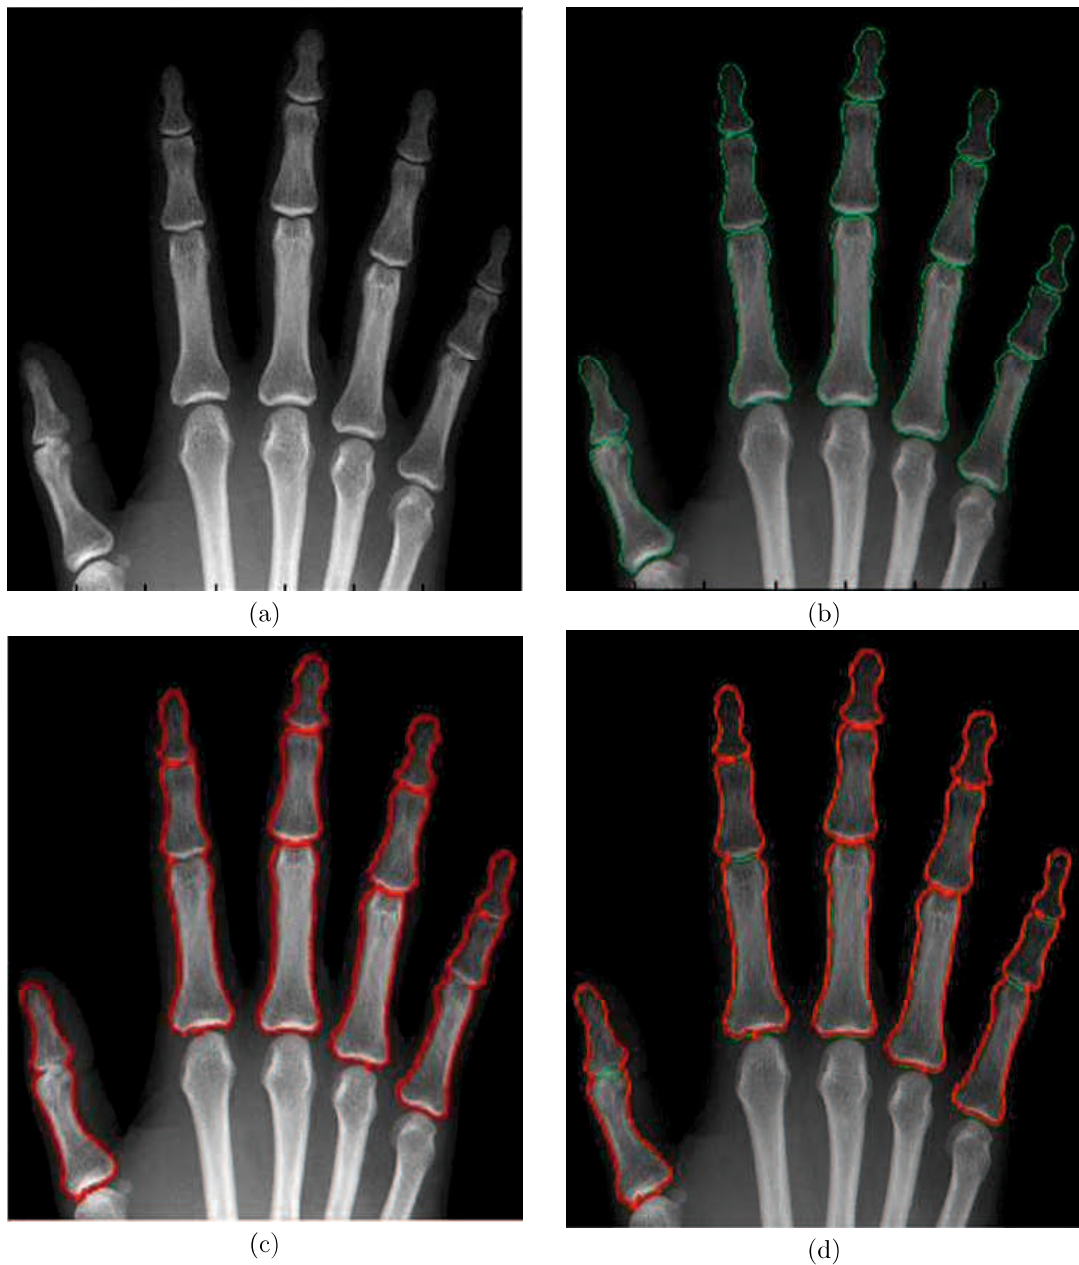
The bone boundary detection results for the right hand radiograph. (a) The right hand bone radiograph to be processed. (b)-(d) The red lines and the green lines show the boundaries detected by the proposed method and those manually detected by an experienced medical doctor, respectively.
